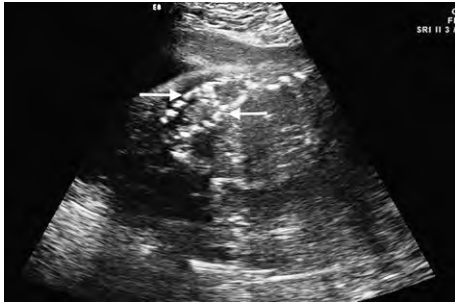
2D ultrasound of myelomeningocele of the lumbar spine cord at 25 weeks of gestation (between arrows).
